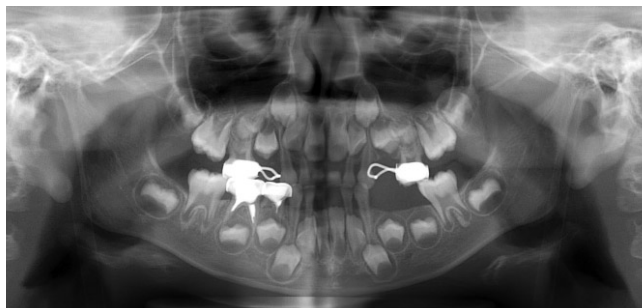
Panoramic radiograph 6 months after insertion of the denture. Note that the both mandibular permanent first molars were fully erupted at the proper position.
